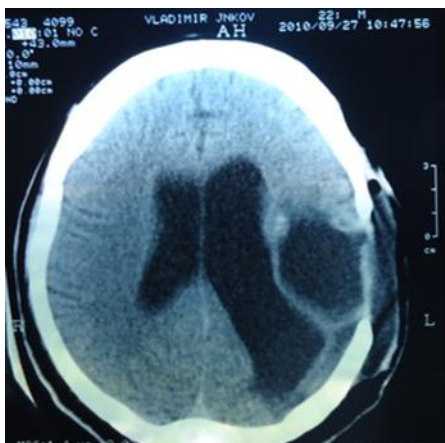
CT image of postoperative brain abscess and asymmetric hydrocephalus
